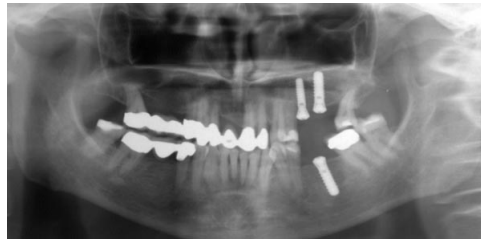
Postoperative radiograph after simultaneous augmentation and implantation
